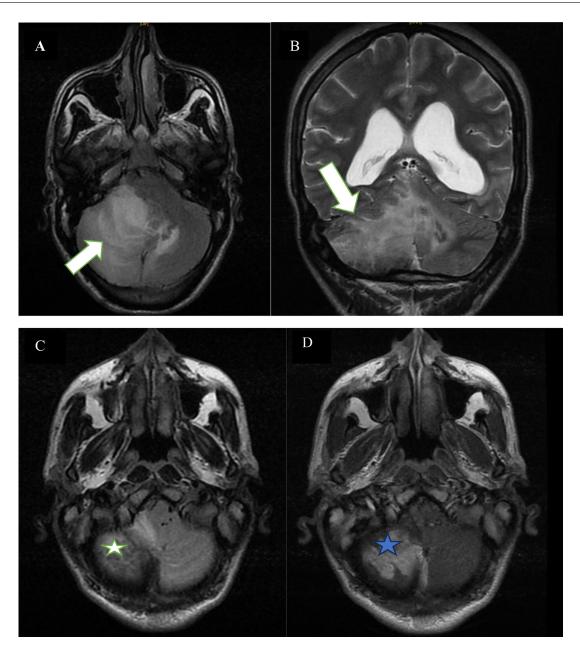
(A-D) Fluid-attenuated inversion recovery axial image and coronal T2-weighted showing hyperintense signal intensity involving right cerebellar hemisphere with mass effect (A, B) (arrow); Axial T2 and Postcontrast fat-suppressed T1-weighted axial image showing nodular leptomeningeal thickening, hypointense on T2-weighted (C) White star taking nodular and heterogeneous contrast (D) Blue star.
